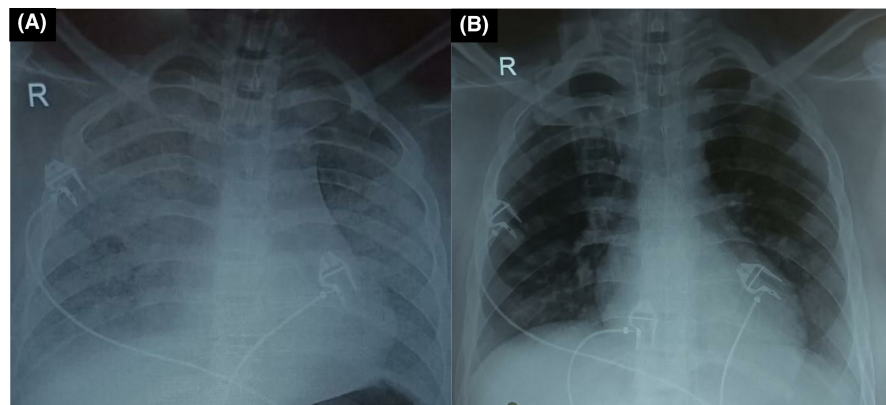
(A) Antero-posterior view of chest radiograph at hospital admission showed evidence of pulmonary edema. (B) Antero-posterior view of chest radiograph after 24 h of hospital admission showed no pulmonary edema
